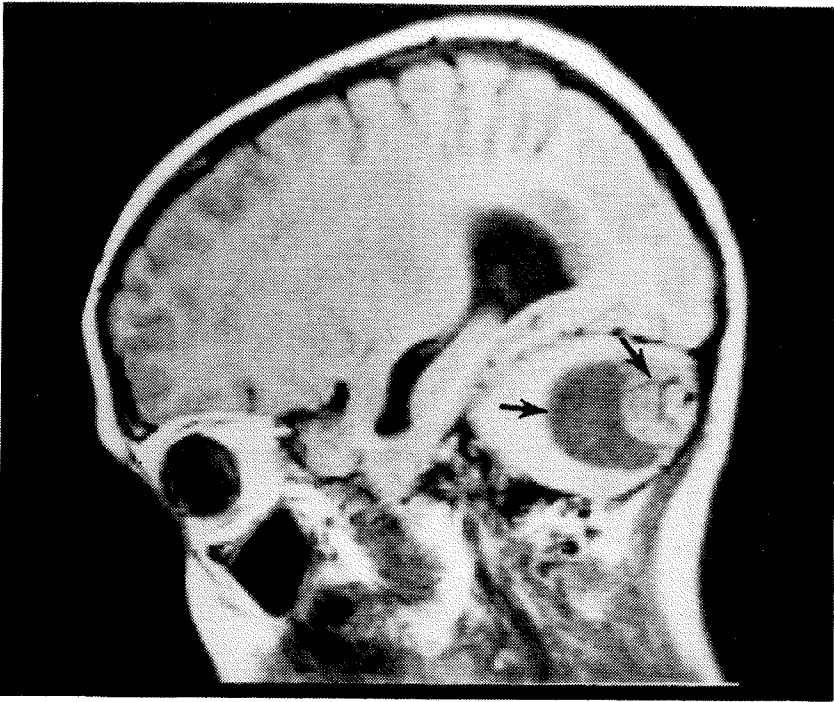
Cerebellar Cystic Haemangioblastoma. Sagittal MR image shows cyst (left arrow) and solid tumour (right arrow), the black serpentine tubes are blood vessels.
